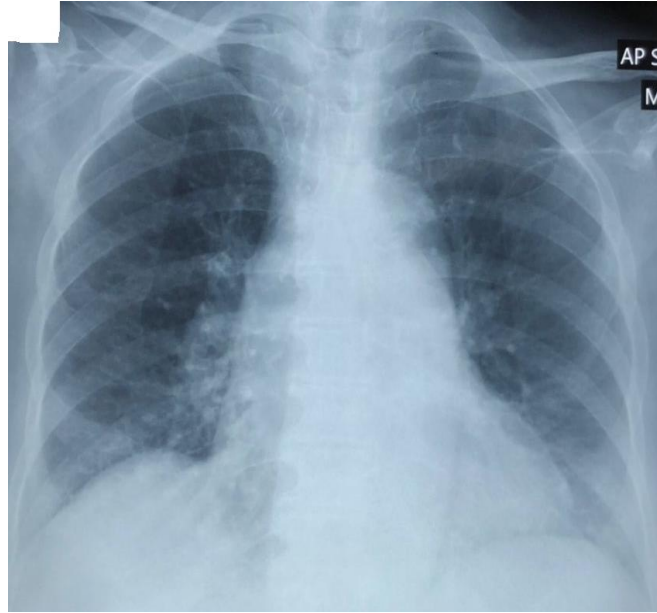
First chest radiograph taken at day-3 of illness. Note the multiple speckled nodules affecting the middle to lower lobes, predominantly right-sided.
